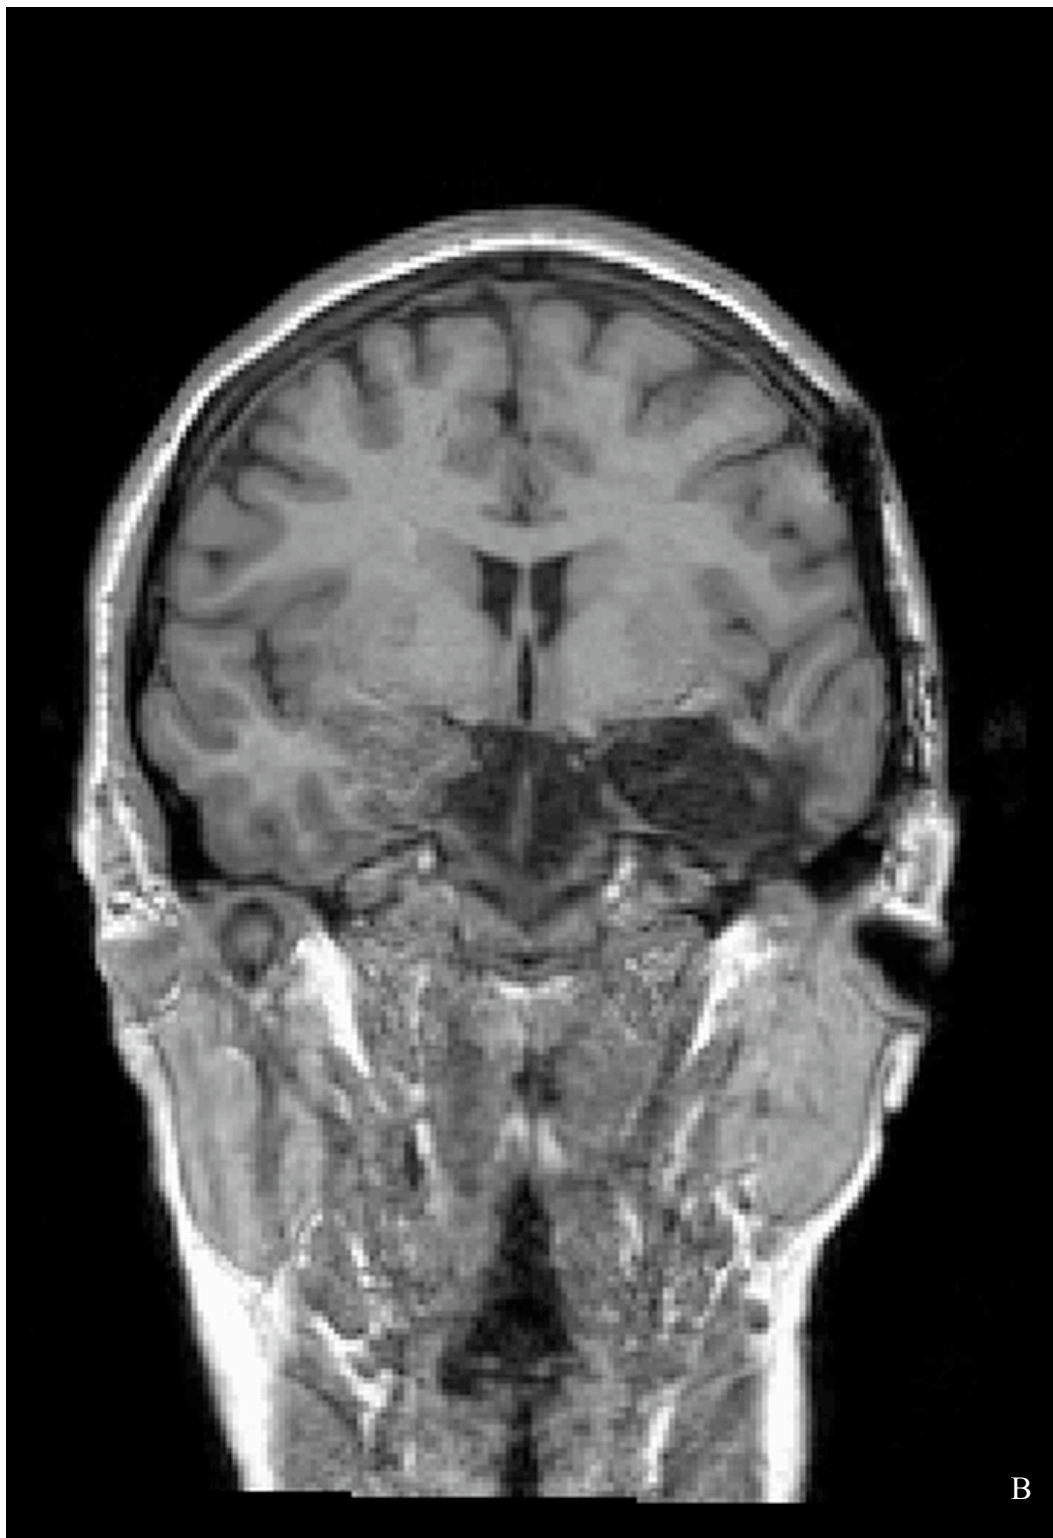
Sagittal (A) and coronal (B) T1W MRI shows the resected area of left temporal lobe > 4 cm from anterior pole.
